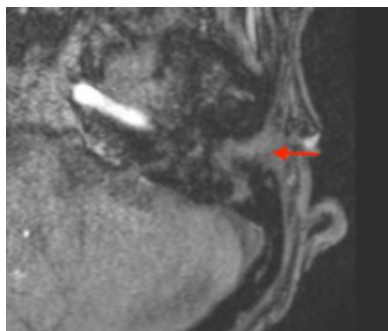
MRI Scan showing erosion of mastoid segment of left temporal
